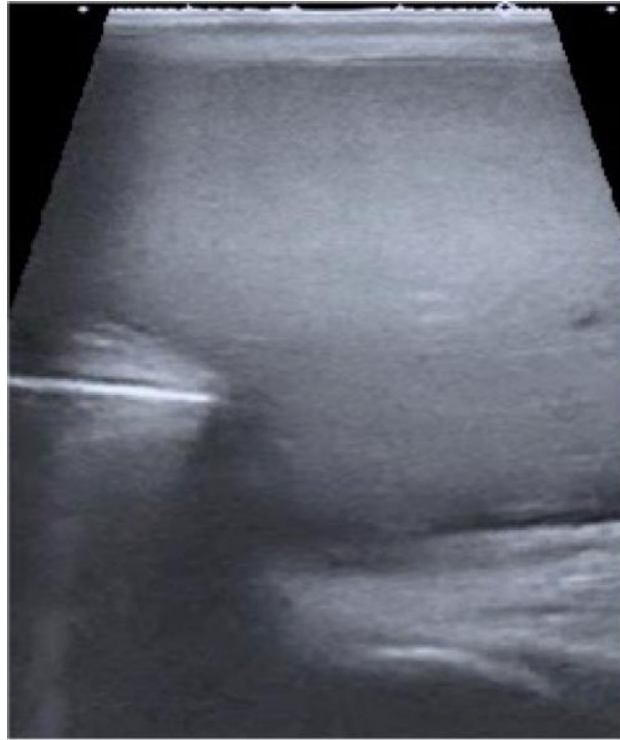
Laparoscopic ultrasound guidance during hematocolpos incision.
